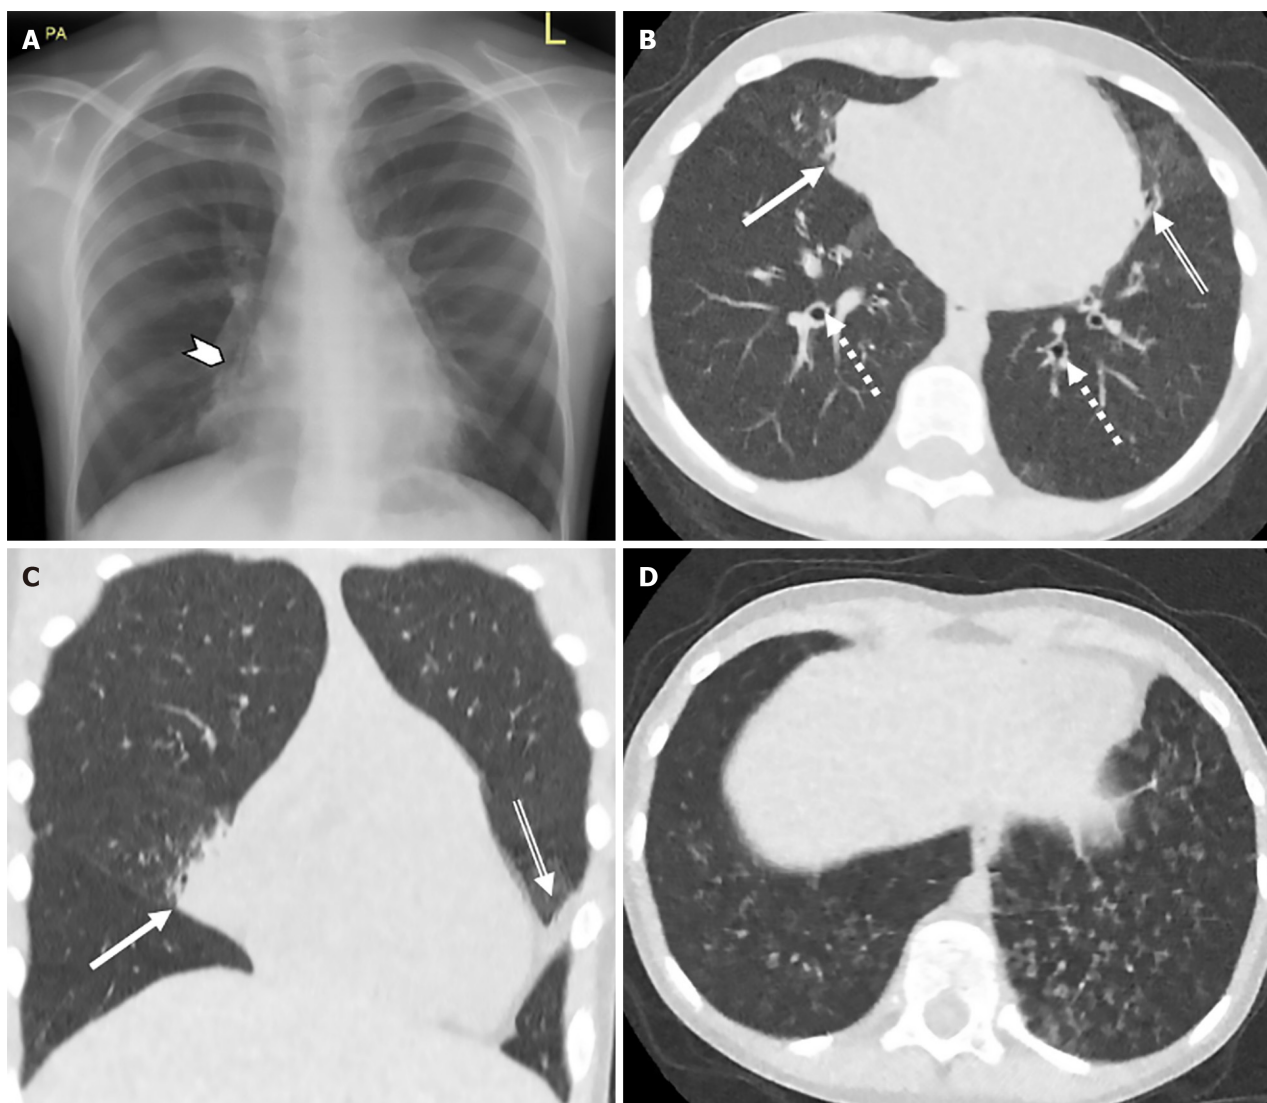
Chest radiography and ultra-low dose computed tomography chest assessment of structural lung pathology. A: Chest radiography; B: Axial ultra-low dose computed tomography (ULDCT); C: Coronal ULDCCT; D: Axial ULDCCT with lung windows of a 7-year-old female with dense medial middle lobe consolidation (solid arrow & arrowhead), bilateral bronchiectasis (dashed arrow), lingular atelectasis (double line arrow) and basal centrilobular ground-glass nodules (D). These representative images demonstrate the superiority of ULDCCT in assessment of structural changes relating to primary ciliary dyskinesia in comparison to plain radiography.
